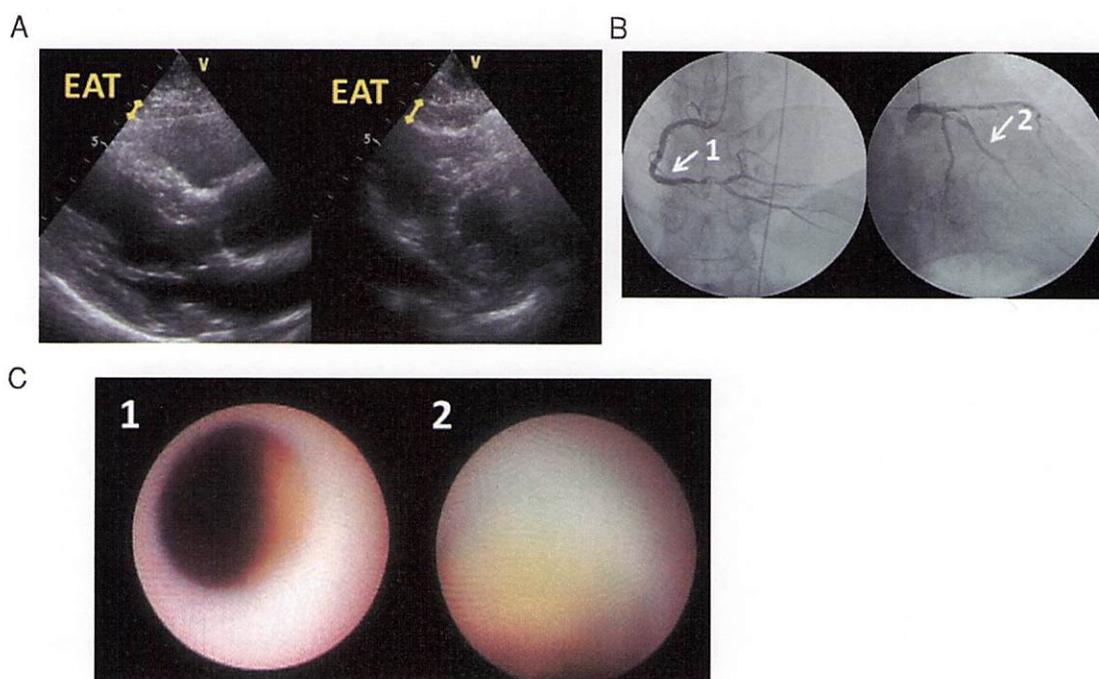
Representative case of an AMI patient with multi-vessel disease. An 80-year-old man with AMI underwent successful primary PCI to RCA. A. Parasternal long- (left) and short-axis (right) 2D echocardiographic images of the epicardial adipose tissue. The mean EAT thickness on the two images is 3.2 mm. B. A coronary angiogram shows a severe stenotic lesion with a filling defect in the RCA and another stenotic lesion in the obtuse marginal branch. White arrows 1 and 2 indicate the plaques observed on coronary angiography. C. Intense yellow plaques detected on coronary angiography.
